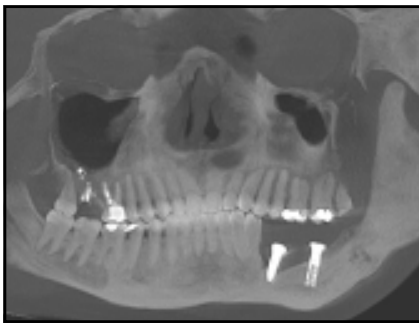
Orthopantomograph showing an ameloblastoma in the left side of the mandible.
